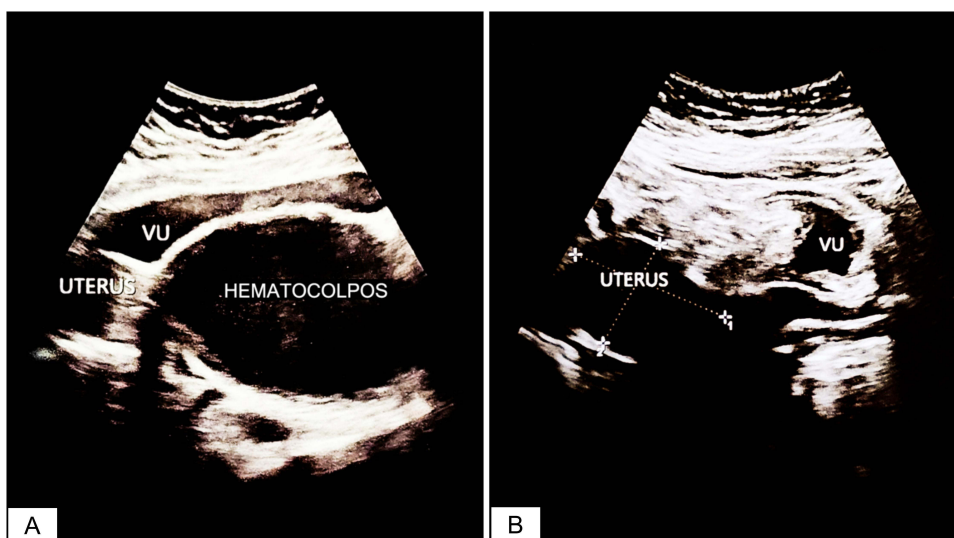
(A) Hematocolpos showed as hypoechoic mass fulfilled the vagina in an ultrasonography; (B) Post-hymenectomy ultrasonography revealed an empty urinary bladder after a complete urination.
